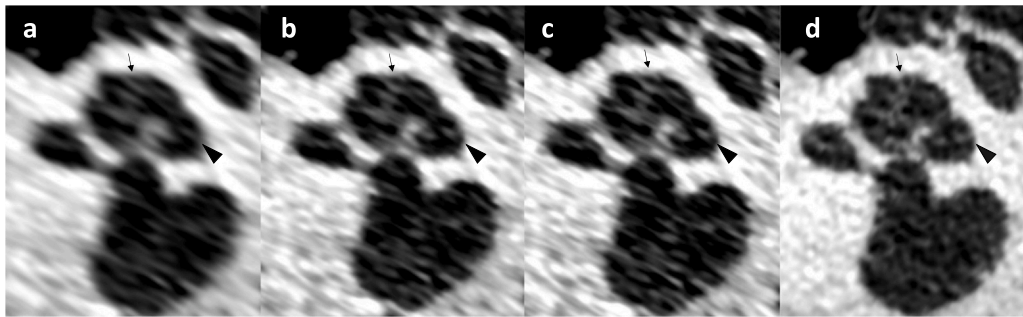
UHR-CT volume scan. Modiolus of the cochlea (arrow). Osseous spiral lamina (arrowhead). (a) HIR NR (AIDR 3D, 512² matrix). (b) HIR UHR 1024 (AIDR 3D, 1024² matrix). (c) HIR UHR 2048 (AIDR 3D, 2048² matrix). (d) DLR UHR 1024 (AiCE Inner Ear, 1024² matrix).
